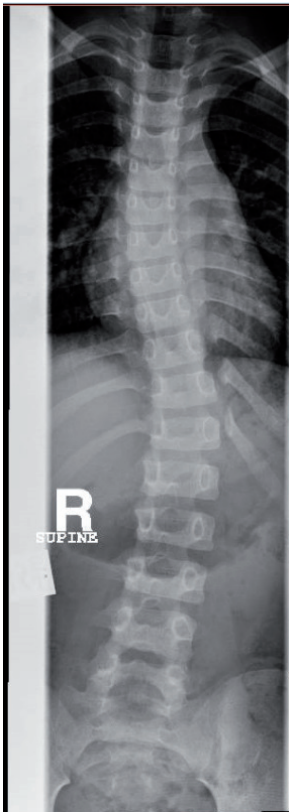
MRI demonstrating scoliosis of the older brother.
